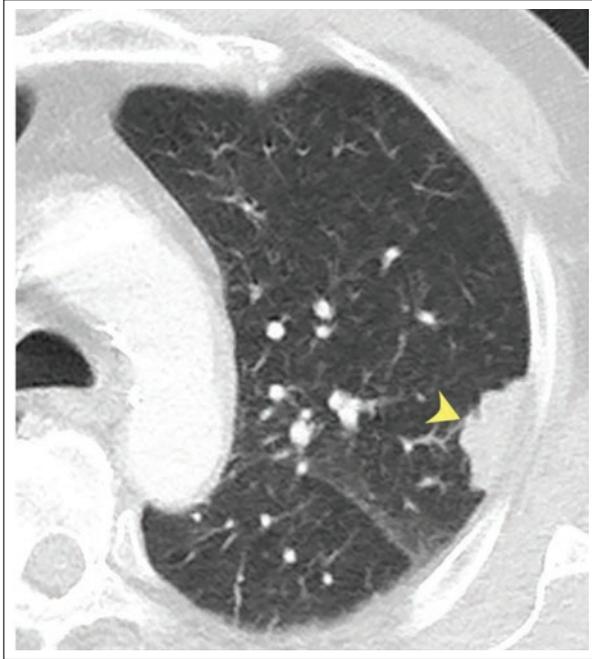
Pleural amyloidosis. Chest CT, axial view showing left apical focal pleural thickening (plaque) with lobulated contours (arrowhead). CT: computed tomography.
